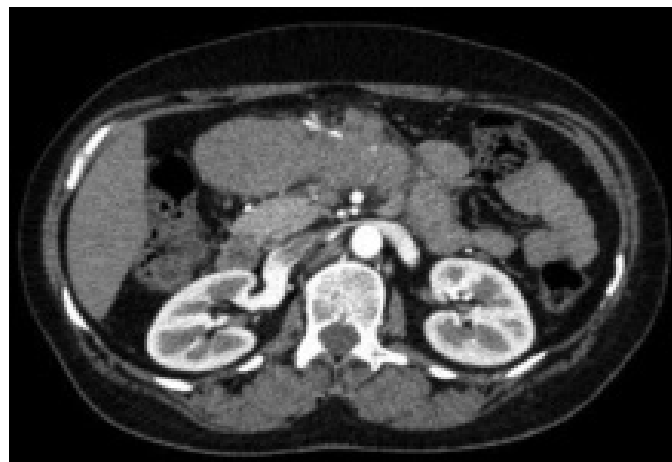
Pancreatic tumor, CT
